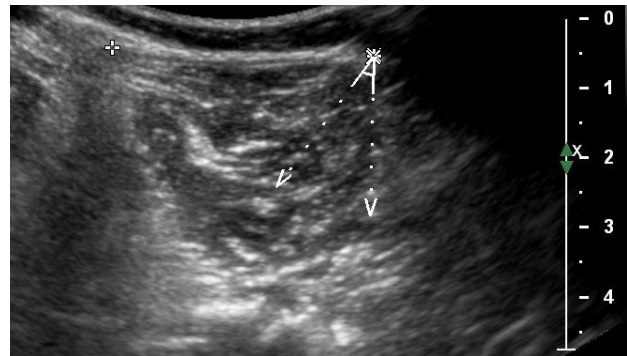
Determination of biopsy angle and depth with ultrasound imaging
